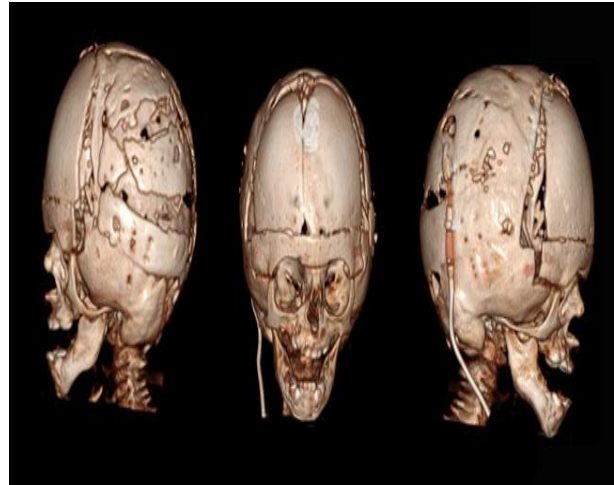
Postoperative CT three-dimensional bone reconstruction showing entire calvarial remodeling and corrected shape
